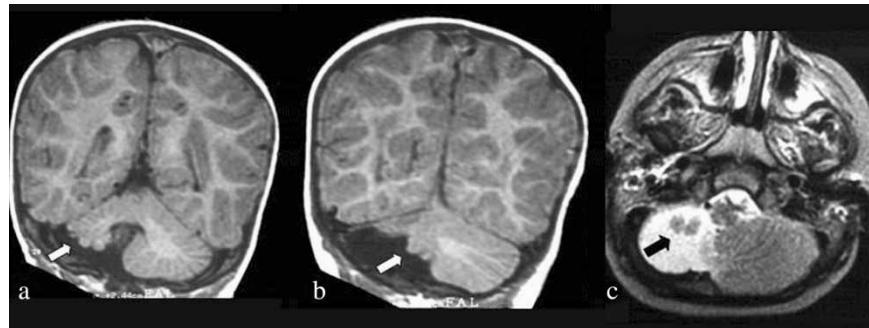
Brain MRI from the patient. a, b) Representative coronal T1-weighted images showing a marked hypoplasia of the right cerebellar hemisphere, associated with a partial hypoplasia of the inferior vermis (arrows), causing a right shift of the cerebellar midline. c) Axial T2-weighted image showing a dilatation of the liquor spaces delimiting the inferior vermis. The liquor fills the right side of the posterior fossa because of cerebellar hemisphere hypoplasia (arrow).
